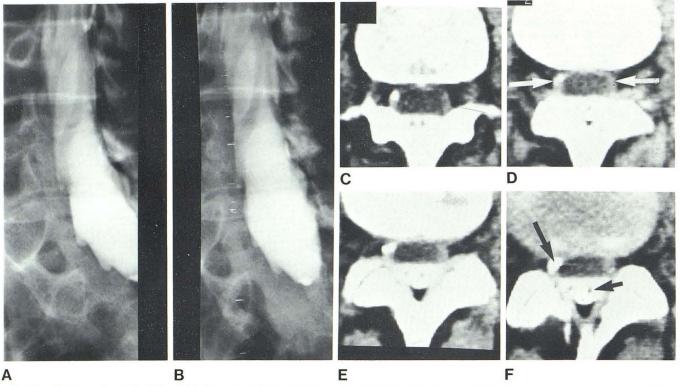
Postoperative arachnoiditis; CT findings. A and B, Metrizamide myelogram. Right laminectomy at L5–S1 shows typical changes of arachnoiditis: blunted nerve root sleeves and thickening of intradural nerve roots in L3–L5 area. C–F, Scans at L4–L5 shortly after myelography. Layered metrizamide (*black arrows*) in sac and in proximal nerve sleeve. Wall of sac is markedly thickened in all sections (*white arrows*), probably representing thickening of dura and arachnoid.
